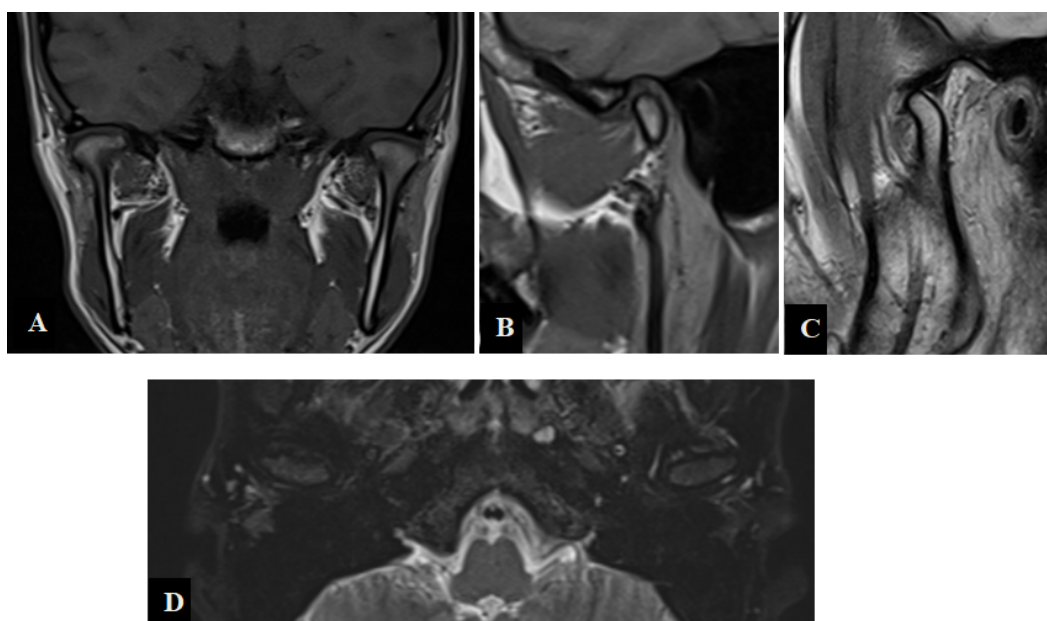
MRI of the temporomandibular joint (TMJ) in a 32-year-old female who presented with mild right-sided jaw discomfort but no clinical signs of dysfunction. MRI was performed to evaluate potential internal derangement. The images reveal degenerative microlacerations of the right articular disc without any associated functional impairment, supporting a conservative, nonsurgical management approach. (A) T1-weighted turbo spin-echo coronal view with the mouth closed. (B) T1-weighted turbo spin-echo sagittal view with the mouth closed. (C) Proton density turbo spin-echo sagittal view with the mouth open. (D) T2-weighted turbo spin-echo with fat saturation and the mouth closed.
